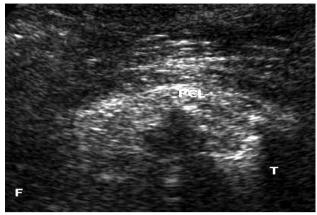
Ultrasound image showing contused thickened PCL with avulsion injury. The avulsed bone fragment is causing posterior acoustic shadowing.
